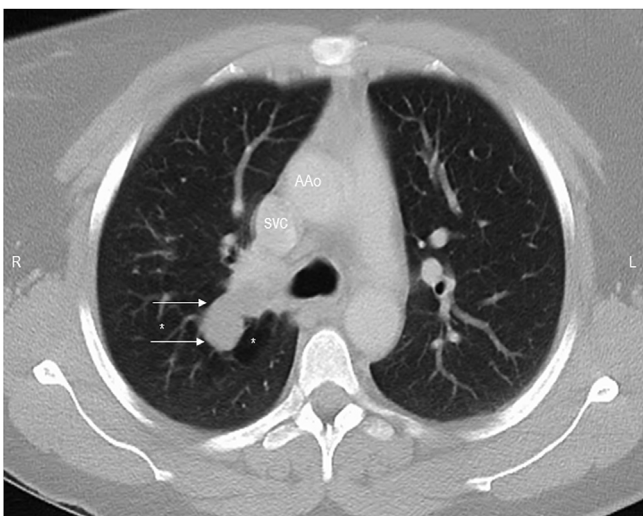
Axial Thoracic CT showed a soft tissue nodule (arrow) measuring 2.5 × 1.7 × 2.6 cm in medial right with surrounding hyperlucency (*). AAo = ascending aorta, SVC = superior vena cava.
